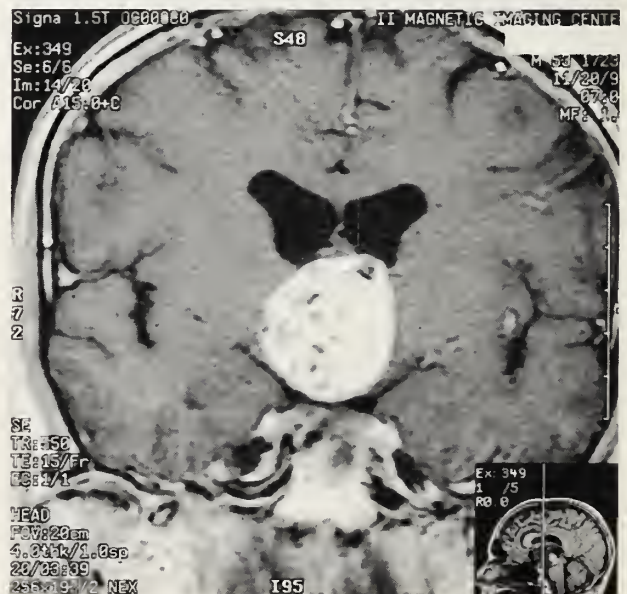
Coronal view of magnetic resonance imaging shows a 4 cm x 2 cm inhomogeneous enhancing suprasellar mass extending into the hypothalamus and to the foramina of Monro. There is an associated moderate hydrocephalus.
